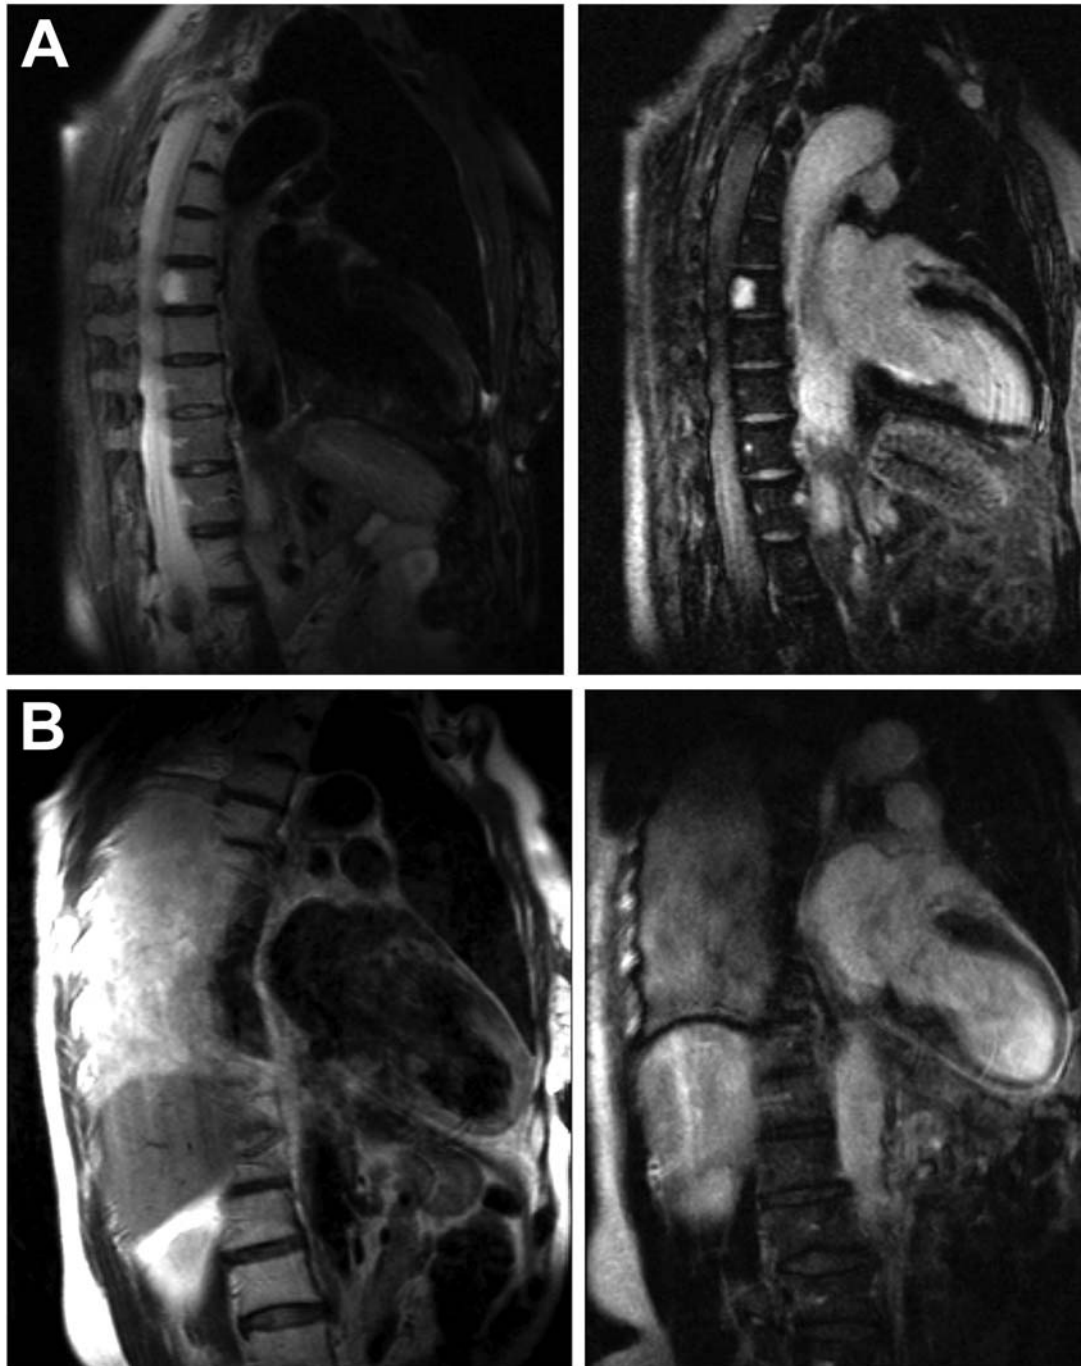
(A) T2-CMR findings: Left panel shows at diagnosis diffuse oedema of the medial and apical portions of the left ventricle. Right panel shows resolution of wall oedema at last follow-up. (B) Gadolinium-enhanced CMR findings: Left panel shows at diagnosis diffuse late enhancement in medial and apical portions of the left ventricle, a magnetic resonance imaging pattern not commonly observed in acute myocarditis. Right panel shows lack of late enhancement at last follow-up.
